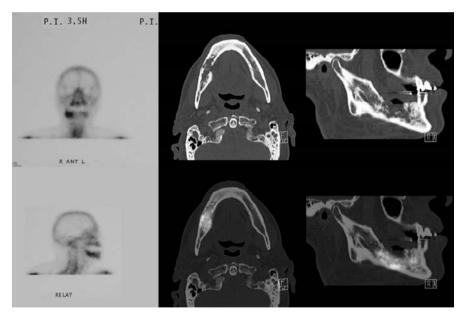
Patient with pain in the jaw and proven osteomyelitis. Diagnostic scintigraphy with ^{99m}Tc-DPD to define the extension of the infectious bone changes. Planar scintigraphic imaging on the left side, SPECT/CT fusion imaging on the right side of the picture.
